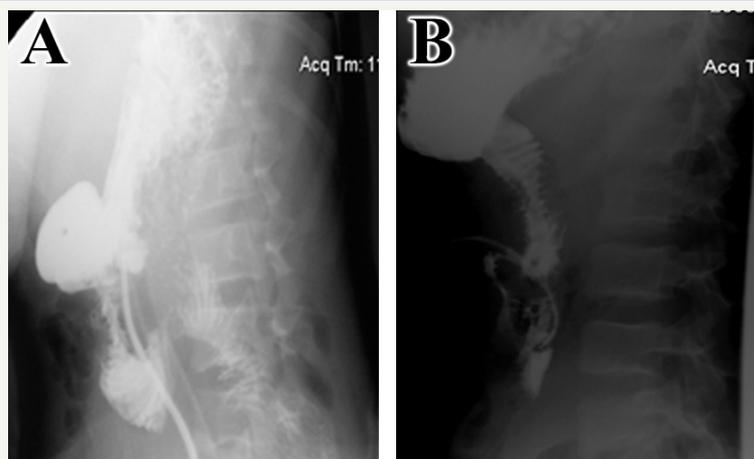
(A) Upper GI series radiography with gastrografin swallow showing significant leak of the contrast material from the lower 2nd portion of the duodenal loop at its junction with the 3rd portion. Two fistulous tracts are demonstrated from this area. The 3rd and 4th portions of the duodenal loop could not be filled. (B) Upper GI series radiography with gastrografin swallow repeated 4 weeks following “triple-tube-ostomy” decompression surgical procedure. Contrast material was injected through gastrostomy tube with no evidence of leak or any fistula from the duodenum. The duodenal loops and upper small bowels show no abnormalities.
